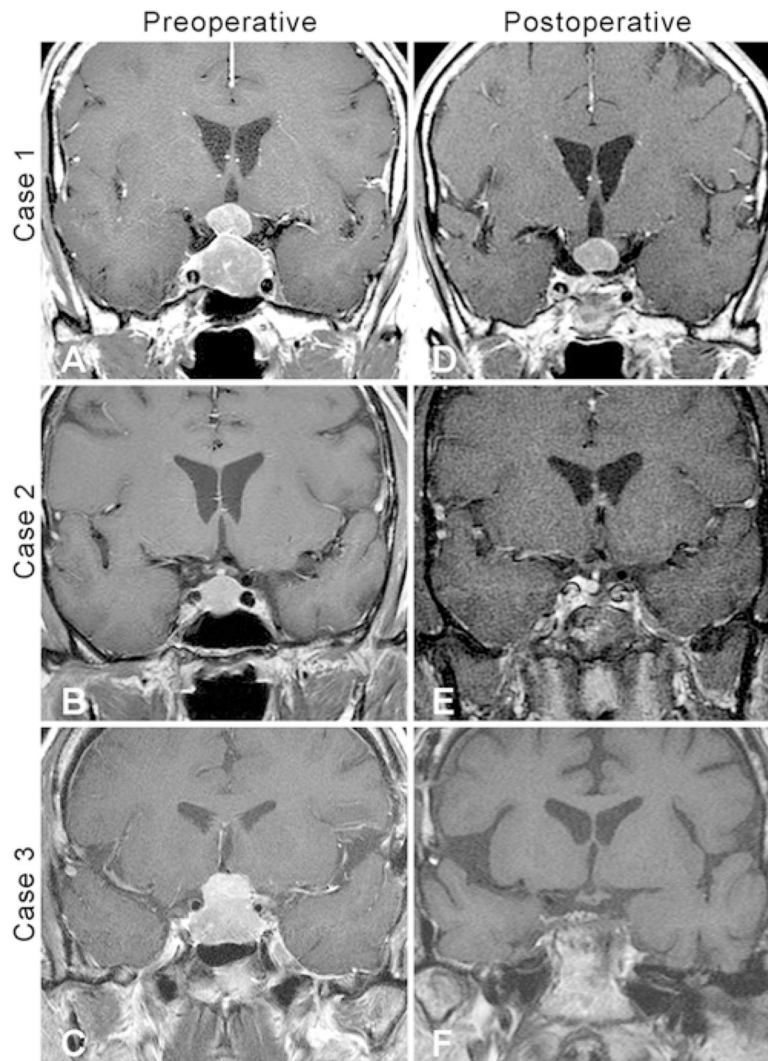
Preoperative and postoperative coronal contrast-enhanced T1-weighted MR images. A: Preoperative image showing a dumbbell-shaped intrasellar and suprasellar SCO (case 1). B: Preoperative image showing an intrasellar tumor that was initially misdiagnosed as a pituitary adenoma (case 2). C: Preoperative image of a SCO obtained after a craniotomy at an OSH (case 3). D: Follow-up image obtained 100 months postoperatively showing stable residual tumor (case 1). E: Follow-up image obtained 30 months postoperatively showing stable residual tumor (case 2). F: Postoperative MR image showing residual after 2 transsphenoidal resections and 2 craniotomies (case 3).
